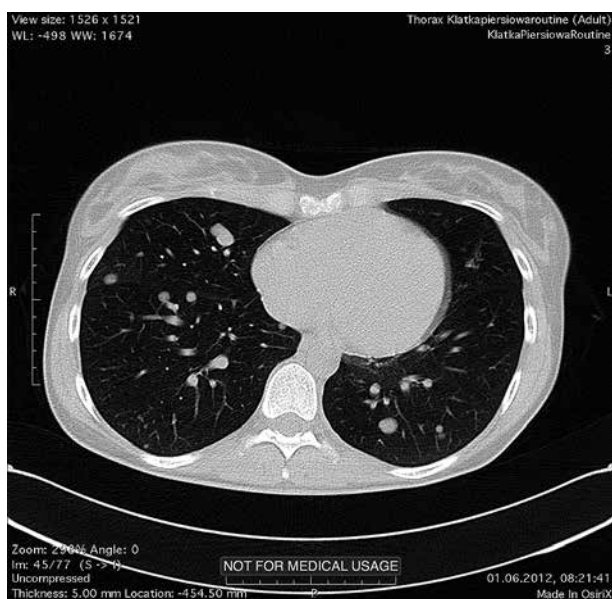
CT scan of the lungs showing multiple, probably metastatic, pulmonary nodular opacities
